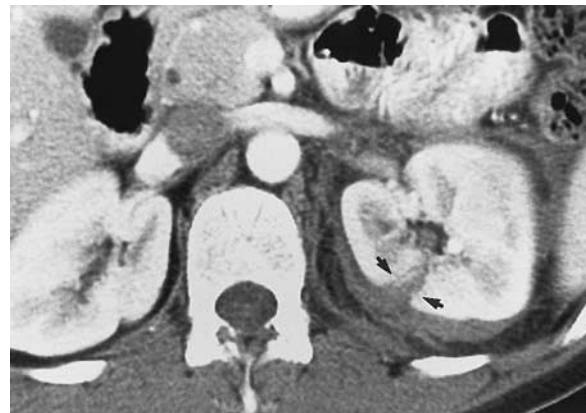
Major renal laceration without involvement of the collecting system (category II) in a 32-year-old woman who had sustained blunt abdominal trauma. Contrast-enhanced helical CT scan reveals a laceration in the posterolateral aspect of the middle portion of the left kidney (arrows) associated with perinephric hematoma. No urine extravasation was seen on excretory-phase scans (not shown).
